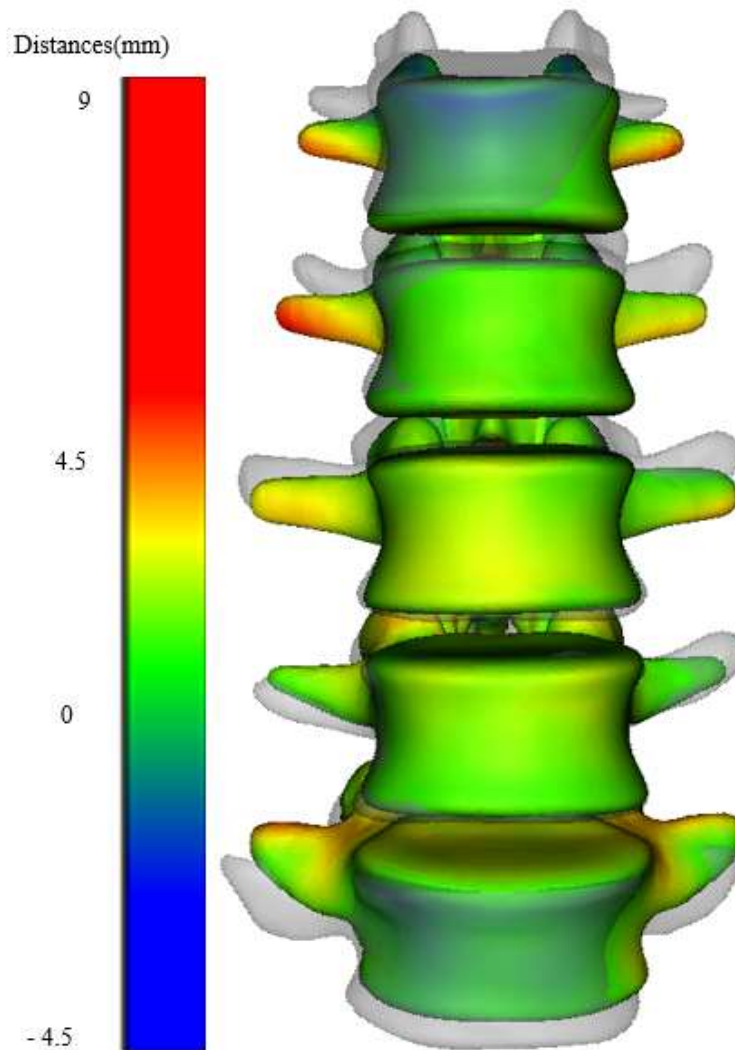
Comparison of lumbar vertebrae (without pelvis and sacrum) prediction with the CT reconstructed mesh (anterior view)
